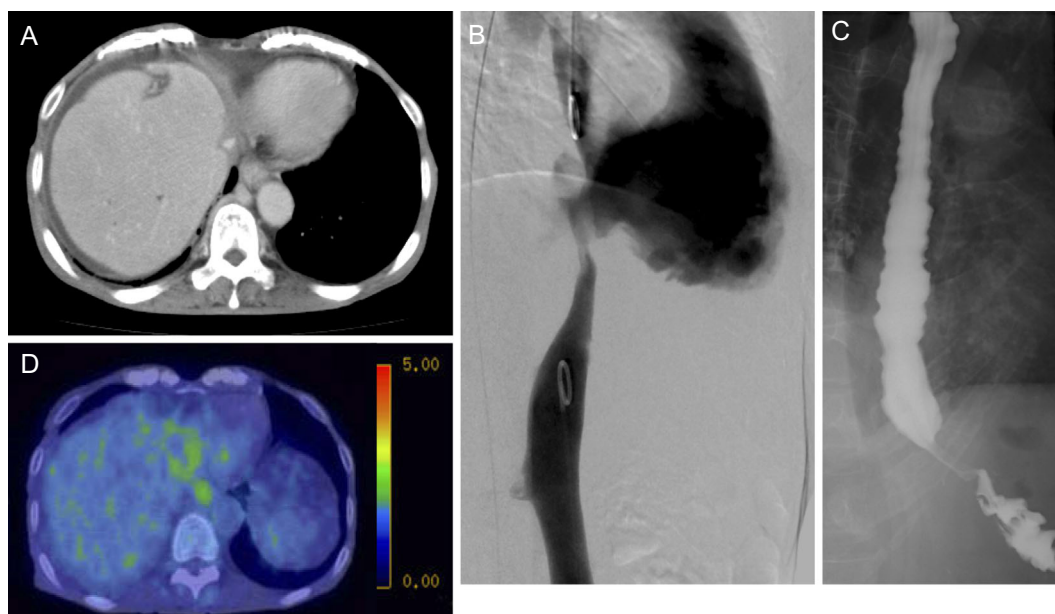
Radiographic studies of the present case. A: Abdominal computed tomography with contrast enhancement revealed an unenhanced lesion near the hepatic vein on horizontal section images. B: Inferior venography showing narrowing of the hepatic segment of the inferior vena cava. C: An esophagogram showing a narrowed segment at the esophagogastric junction. D: Positron emission tomography combined with computed tomography showing an abnormal accumulation around the inferior vena cava and esophagus.
